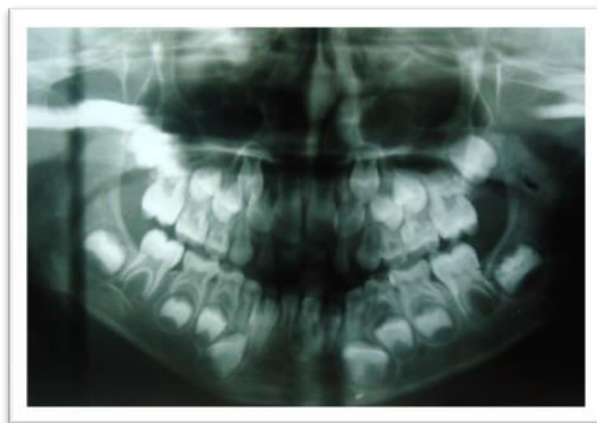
shows preoperative radiographs of the patient
